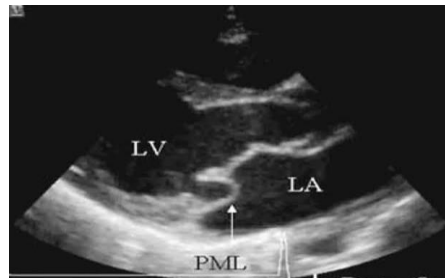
2-D ECHOCARDIOGRAPHIC IMAGE OF MV PROLAPSE
